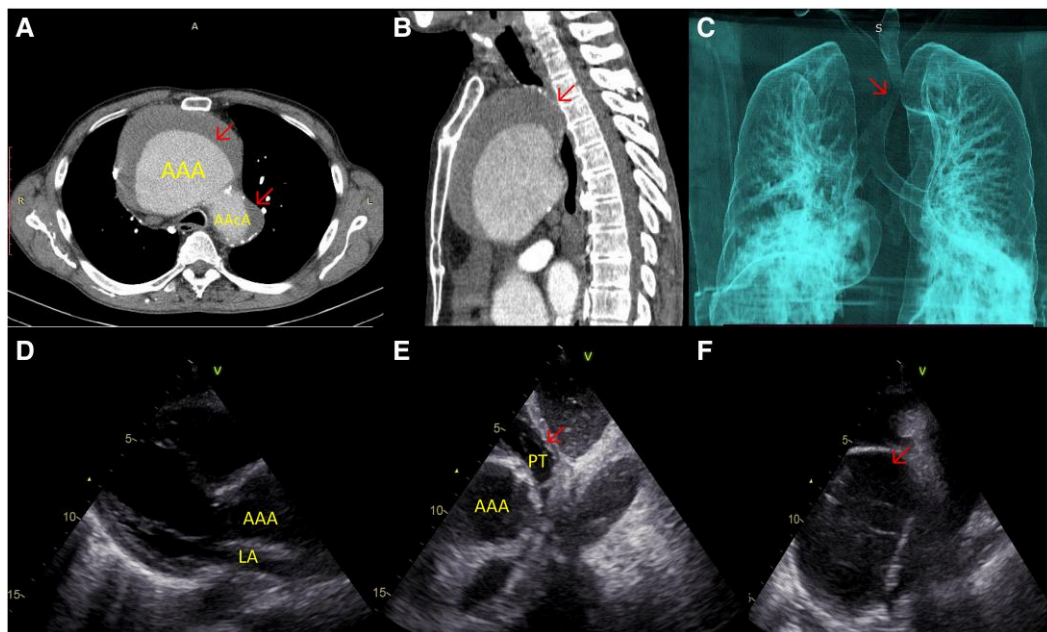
Panel A-F. (A) Computed tomography angiography, axial view, at the level of the thorax, showing two aneurysmal dilations with haematic densities around them, the first one at the level of the ascending aorta ($64 \times 95 \times 112$) and the second one at the aortic arch ($60 \times 50 \times 45$). (B) Angio-computed tomography, sagittal view showing the impressive aneurysm at the level of ascending aorta, compressing the intra-thoracic segment of the trachea. (C) Three-dimensional reconstruction, showing the important tracheal compression, caused by the aneurysm. (D) Transthoracic echocardiography showing the compression of the left atria. (E) Transthoracic echocardiography showing the compression of the pulmonary trunk and valve opening impairment due to high pressure within the artery. (F) Transthoracic echocardiography showing the false lumen inside the dissected aneurysm. AAA, ascending aorta aneurysm; AAcA, aortic arch aneurysm; LA, left atrium; PT, pulmonary trunk.
